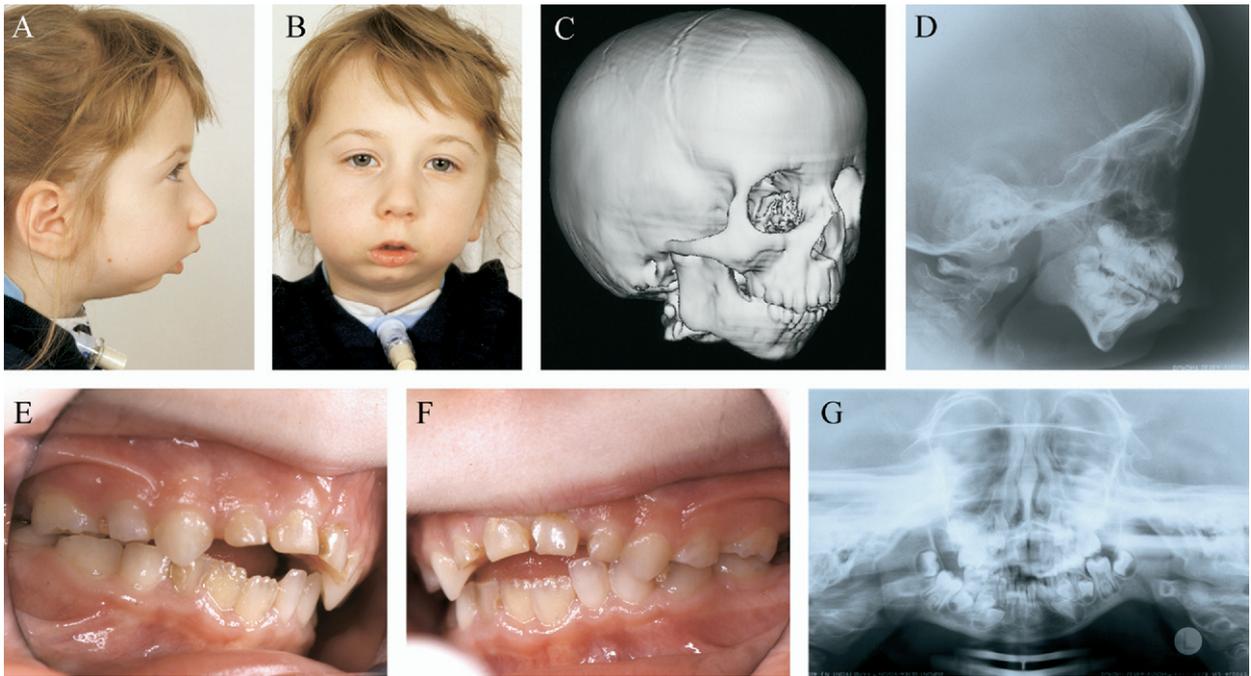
Posttracheostomy records at 7 years 6 months: A and B, facial photographs; C, 3-dimensional computed tomography scan; D, cephalometric radiograph; E and F, intraoral photographs; G, panoramic radiograph.
